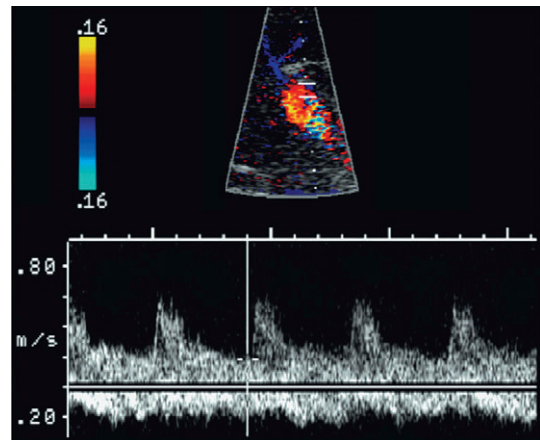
Combined spectral Doppler tracing of the left branch of the portal vein and hepatic artery in a patient with an appropriately functioning TIPS. The sample volume is opened wide in position so that both vessels are interrogated in the same tracing. Note flow in the hepatic artery is towards the transducer, therefore into the left lobe of the liver. The left portal vein flow, however, is away from the transducer, therefore hepatofugal and towards the inflow of the shunt.
